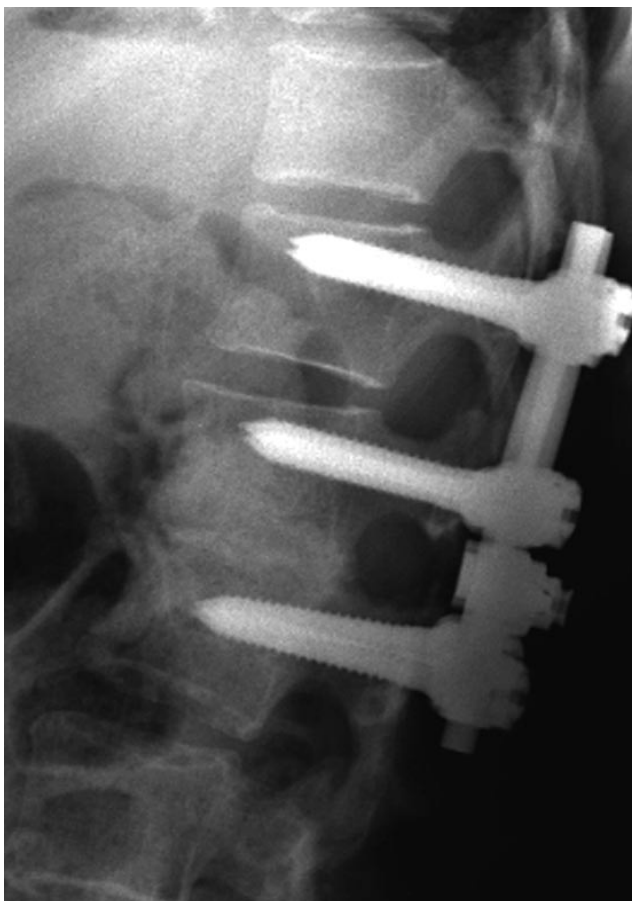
Postoperative plain radiograph (lateral view) shows T12–L2 instrumentation with posterior lumbar interbody fusion at L1–L2. Autogenous bone was packed into remaining disc space.
